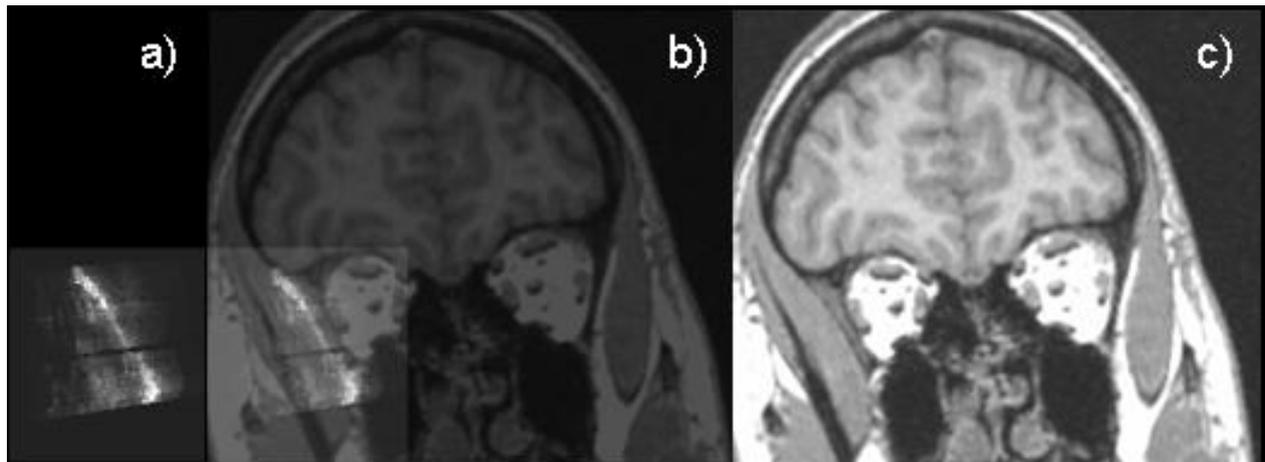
(a) Frontal reconstruction of the three dimensional ultrasound data; (b) superimposed ultrasound and registered MR image; (c) corresponding frontal MR slices
